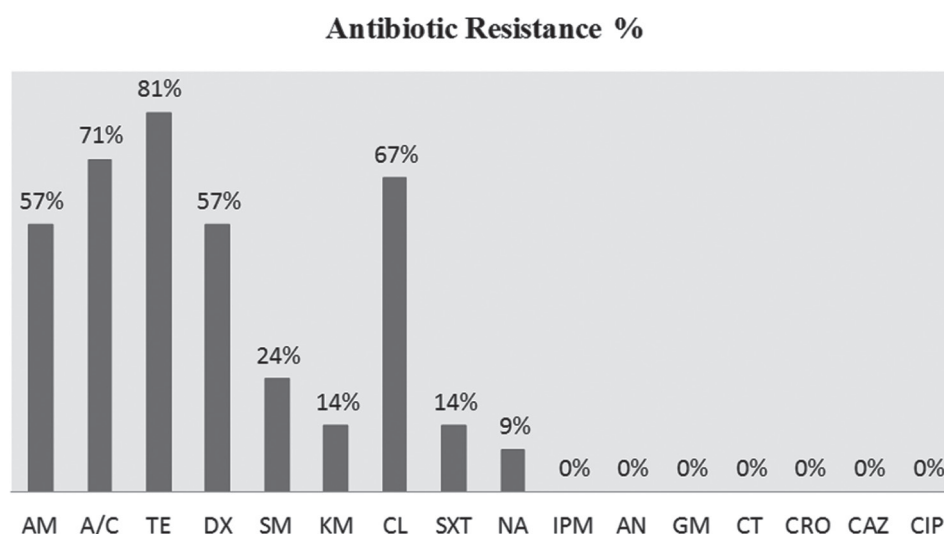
Rate (%) of antibiotic resistance in *Salmonella* Typhimurium strains isolated from clinical samples from Tehran hospitals. AM: Ampicillin; A/C: Amoxicillin/clavulanic acid; TE: Tetracycline; DX: Doxycycline; SM: Streptomycin; KM: Kanamycin; CL: Chloramphenicol; SXT: Trimethoprim/sulfamethoxazole; NA: Nalidixic acid; IPM: Imipenem; AN: Amikacin; GM: Gentamicin; CT: Cefotaxime; CRO: Ceftriaxone; CAZ: Ceftazidime; CIP: Ciprofloxacin.
